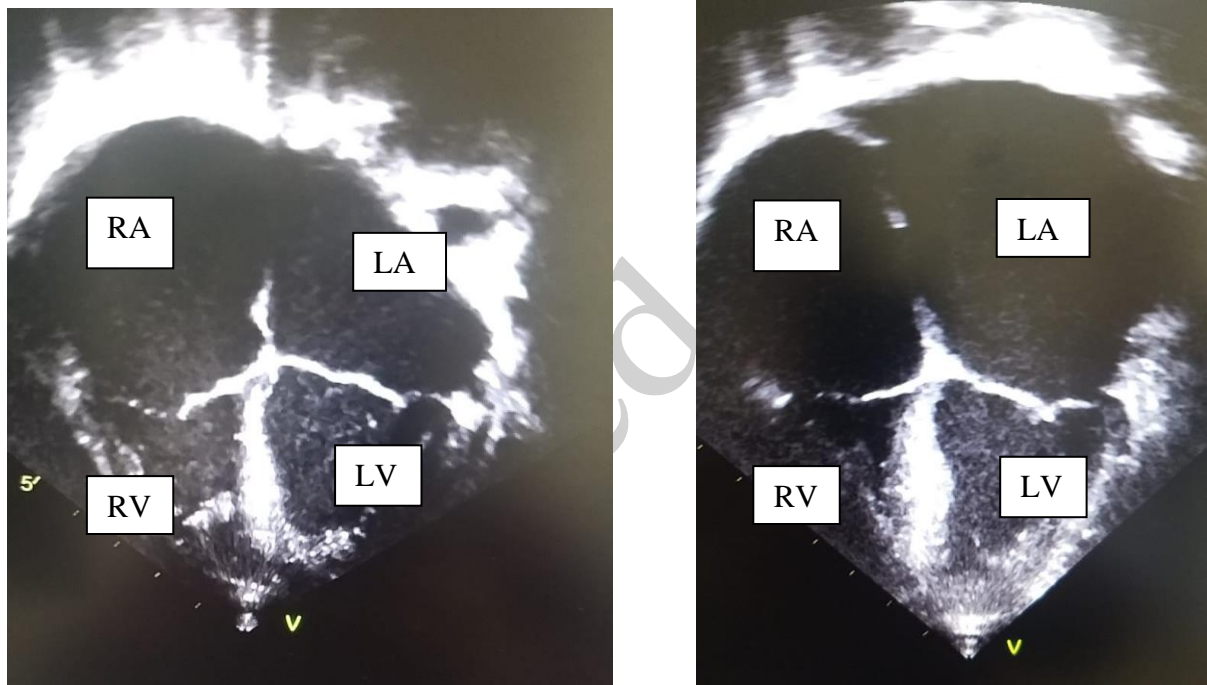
Echocardiography of case 1 (left), and case 2 (right)
